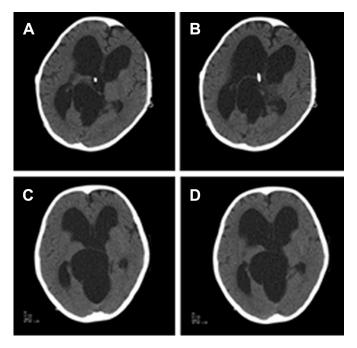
Detection of brain ventricle retraction by computed tomography (CT) scan.
